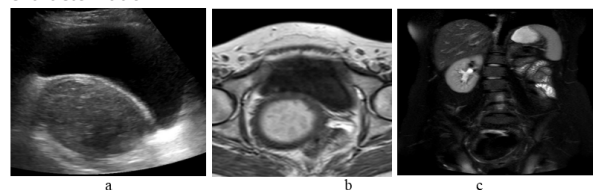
Unicornuate uterus (type II Mullerian Anomaly): a: USG showing bulky uterus with heterogeneous predominantly hyperechoic collection in endometrial cavity. b: MRI shows unicornuate uterus with gross collection in single right uterine horn and associated thinning of surrounding myometrium. c: Associated left renal agenesis.
